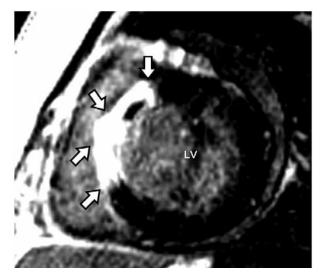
Typical cardiac magnetic resonance imaging findings for myocardial infarction show early subendocardial perfusion defects and subendocardial or transmural delayed segmental enhancement in a vascular distribution.
